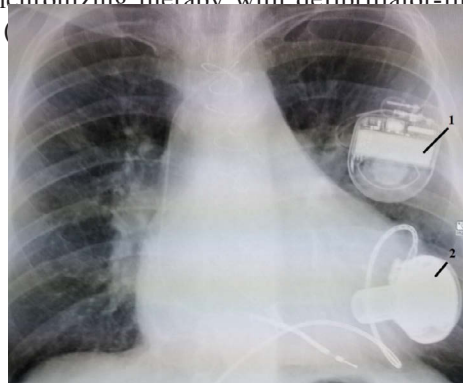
Chest X-ray of patient P. with implanted LVAD device with centrifugal type and cardioverter-defibrillator. (Note: 1 – ICD, 2 – left ventricular support device (LVAD)).
